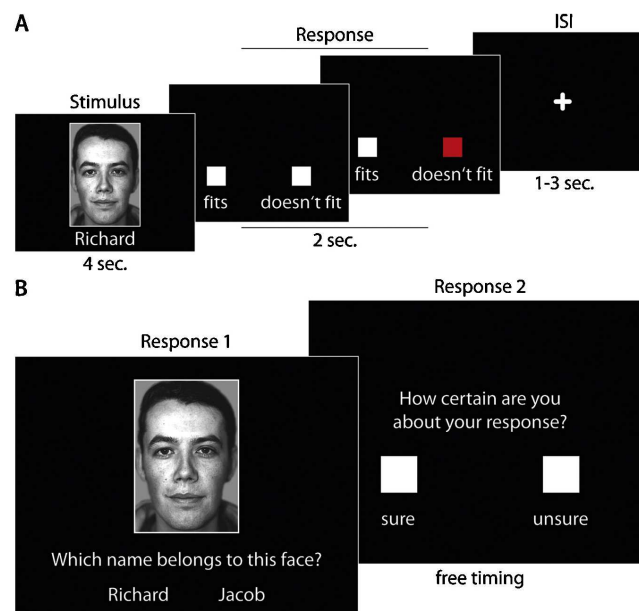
Example trial of (A) the associative memory encoding task performed during event-related functional magnetic resonance imaging and (B) the offline retrieval task performed in the scanner directly after the functional scan. Abbreviations: ISI—inter-stimulus-interval.
